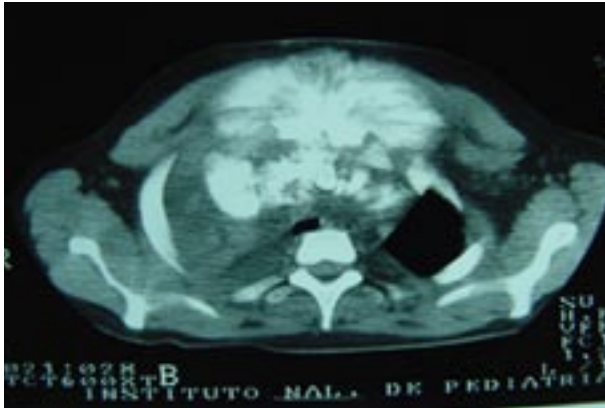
Chest CT scan showing that the osteoblastic mass extends beyond the sternum and involves the lung parenchyma bilaterally.
